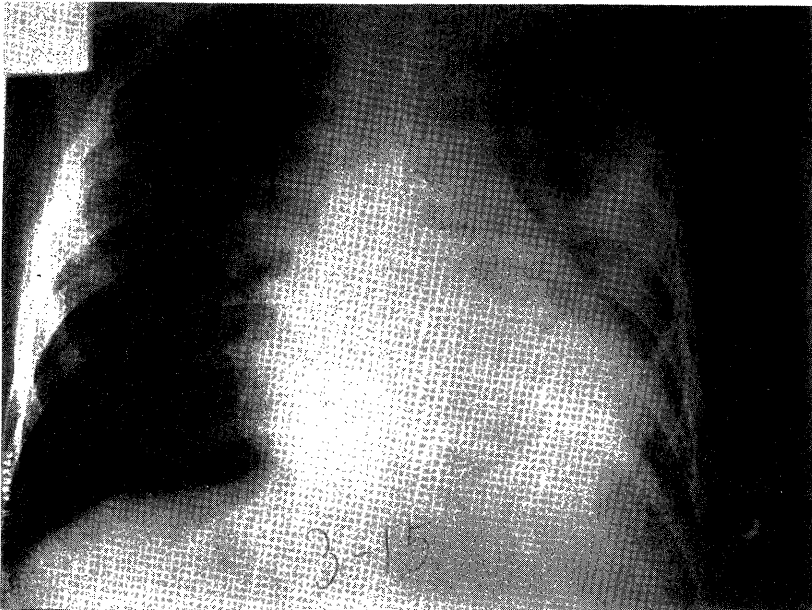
Pre-embolization chest roentgenogram with severe congestive heart failure.
